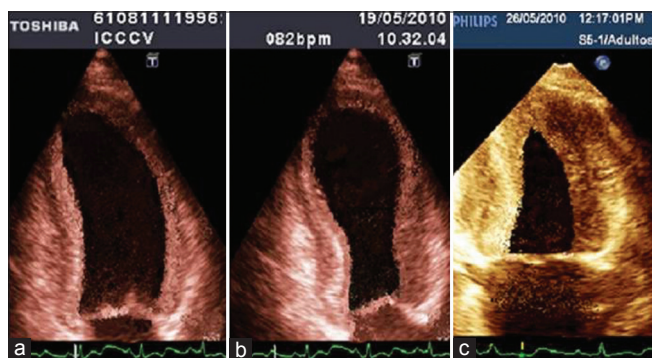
Echocardiography images (Two-chamber long axis) (a-b) Acute onset (a) End-diastole (b) End-systole (c) Two months later
